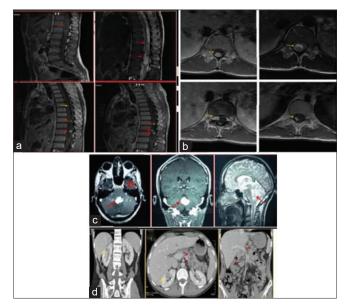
Von Hippel Lindau Disease. MRI of the Spine has showed multiple spinal tumors. The symptomatic lesions is on the medullary conus (Red Arrow). The mass shows a cystic form with a mural nodule tissular heterogenous hypointense on T1 with an intense enhancement. (a, b) The Cerebral MRI shows a cerebellar hemangioblastoma (c) Abdominal CT scan showed two renal masses associated to multiple pancreatic cysts (d)
